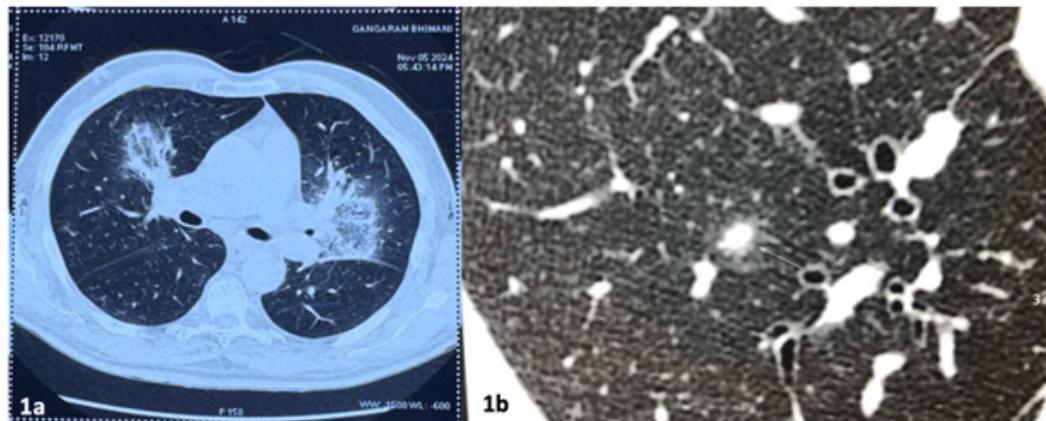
1a CT scan plain study showing RHS, 1b dense nodule with halo (magnified image)
